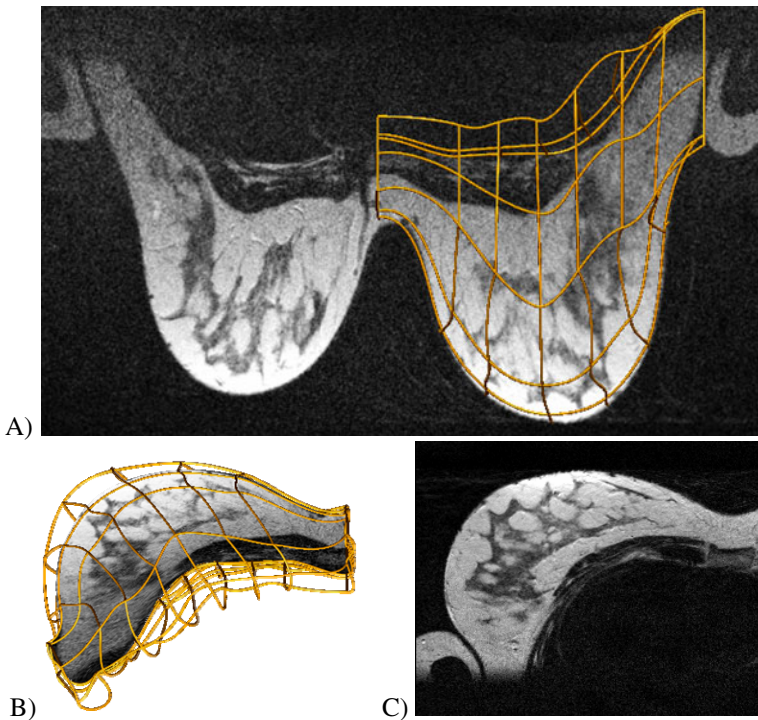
A) Clinical MR images of the prone breast were used to create a personalised FE model for each volunteer. B) This model was used to predict the supine orientation, and thus warp the prone MRI data. This model-warped image was then compared against the clinical supine image shown in (C).
